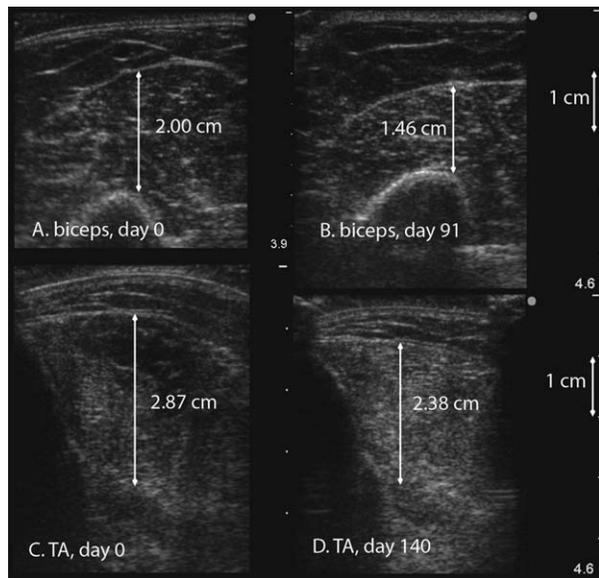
Right biceps brachii ultrasound images on initial examination (A) and at follow-up examination approximately 3 months later (B) in a subject with ALS. Muscle thickness decreased by 27%, from 2.00 cm to 1.46 cm. EI does not appear to have changed. Biceps strength was 5/5 on the MRC scale on both occasions. In a different subject with ALS, right tibialis anterior ultrasound images are shown on initial examination (C) and at follow-up examination approximately 5 months later (D). Muscle thickness decreased by 17%, from 2.87 cm to 2.38 cm. EI increased somewhat in this example, with whiter-appearing muscle tissue in (D) compared with (C). Foot extension strength was 4⁺/5 on the MRC scale on both occasions. Ultrasound images have been rescaled to equilibrate the scales of the images. MRC, Medical Research Council.
